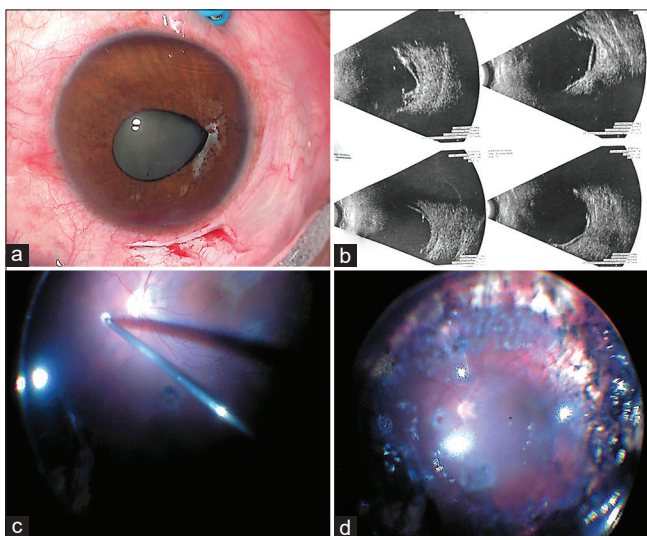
(a) Small rigid pupil with mature cataract. (b) Ultrasound Bscan image showing the retinal detachment. (c) Shallow retinal detachment seen intraoperatively. (d) Silicone oil filled eye
